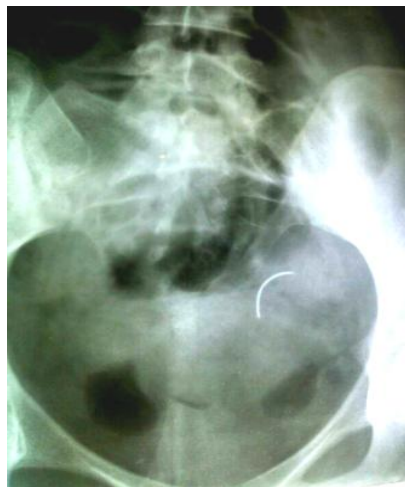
Radiograph showing the broken needle fragment
